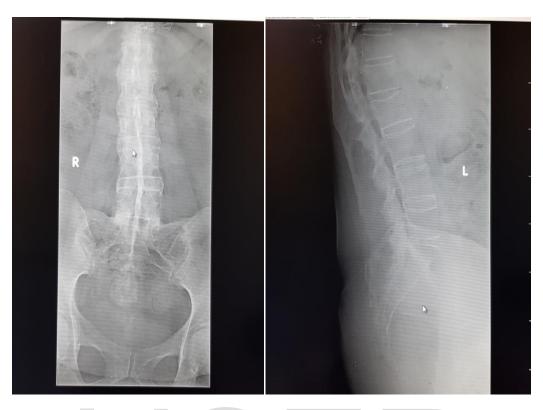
The X-rays of the patient (AP and Lateral views) showing bamboo spine and dagger spine signs with syndesmophytes formation and squaring of vertebral bodies.
